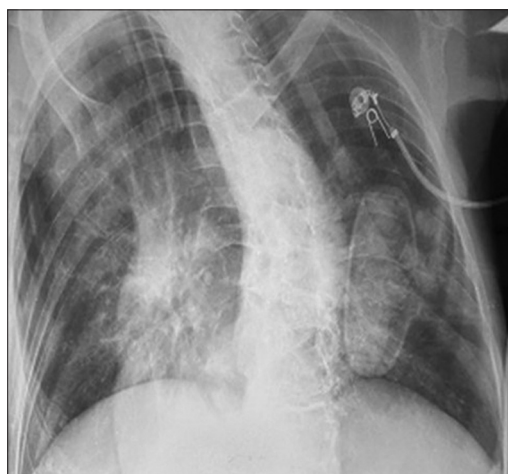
Chest X-ray demonstrating aspiration-consistent infiltrates in the middle and lower zones of both lungs
